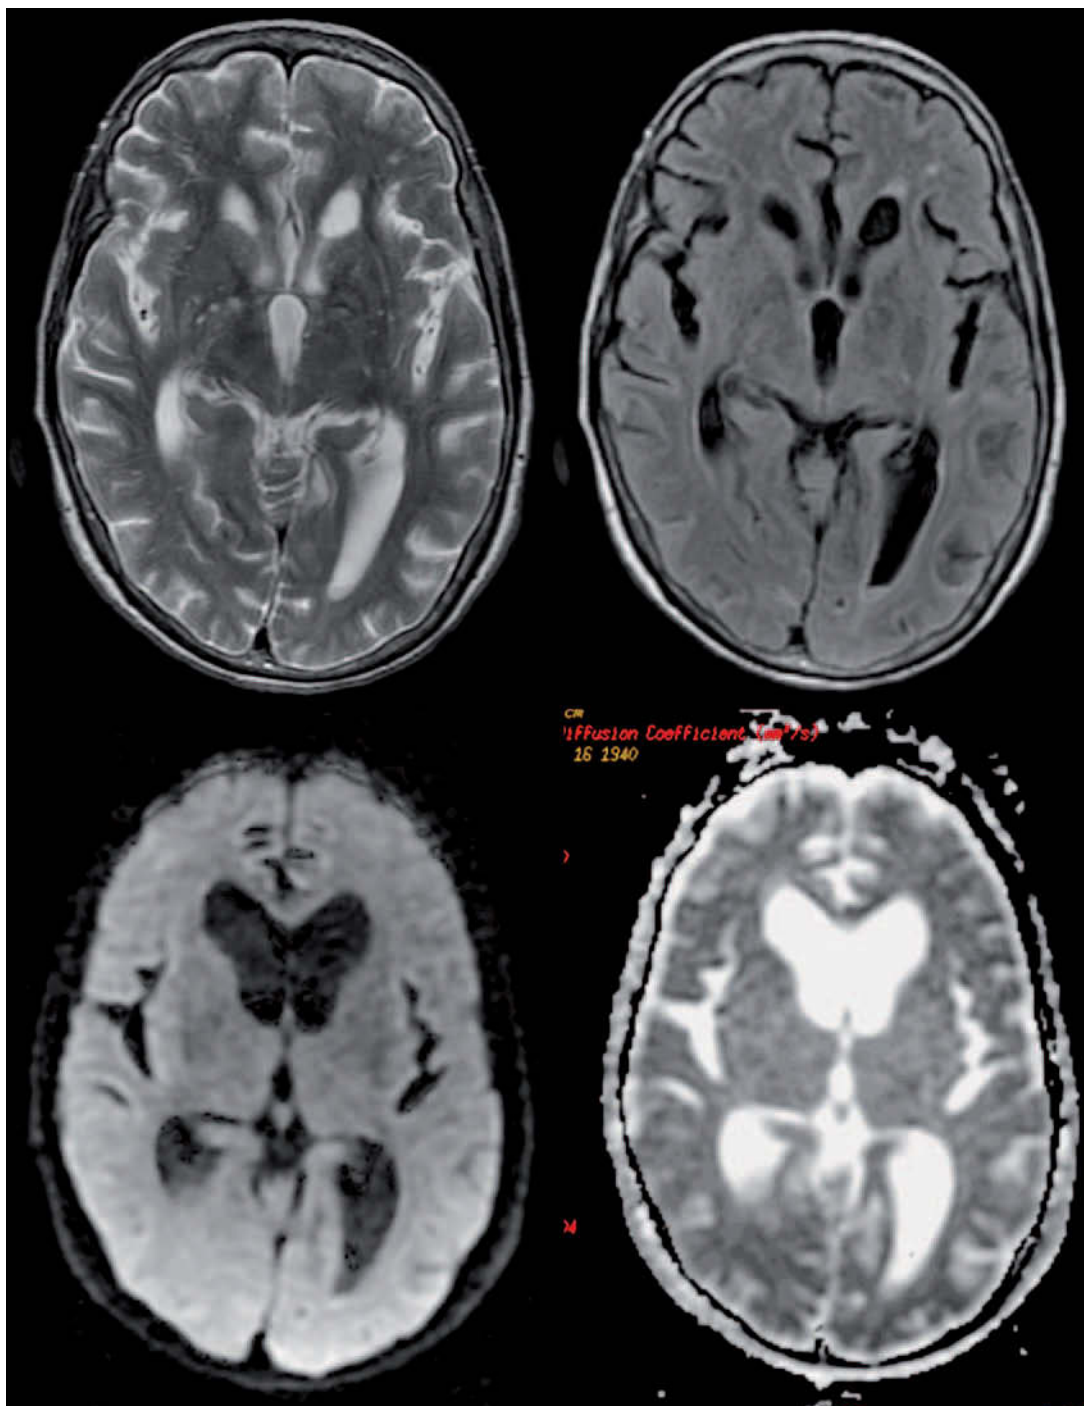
Cerebellar MRI (T2 sequences, FLAIR) that shows a straight liquid-solid level in the left occipital horn with a restriction of free water diffusion (DWI and ADC sequences).
